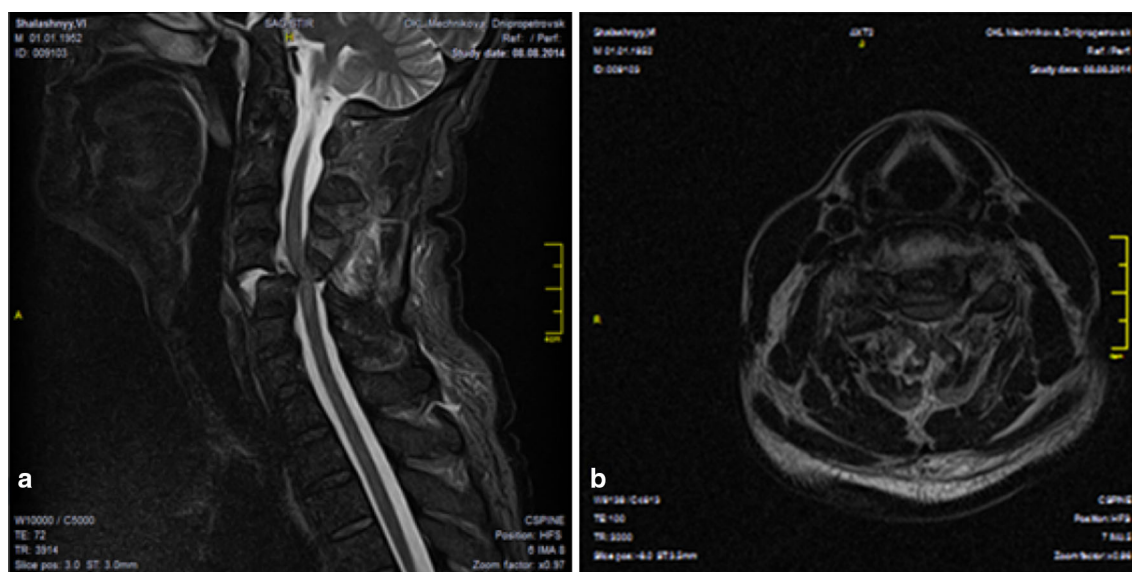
Magnetic resonance imaging of Case 1. A dislocation fracture of C4–C5 can be observed, along with myelopathy at the level of C4–C5. a Sagittal view. b Axial view
